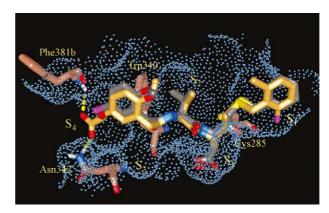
Compound 13 (gold) modelled into the active site of the X-ray structure of the complex between compound 10 (grey) and rh-casp-3 (pink); the two inhibitors virtually superimpose for their common structure from P₁ to P₃. In S₄, yellow dotted lines show the hydrogen bonding between the glycolate of compound 10 and the protein (Asn342 side chain and Phe381b main chain), the same hydrogen bonding present in the substrate Ac-DEVD-CHO. Above S₃, behind the plane of the figure, the edge of the Trp340 indole ring can be seen making an edge-to-face interaction with the phenyl ring for both compounds 10 and 13.
